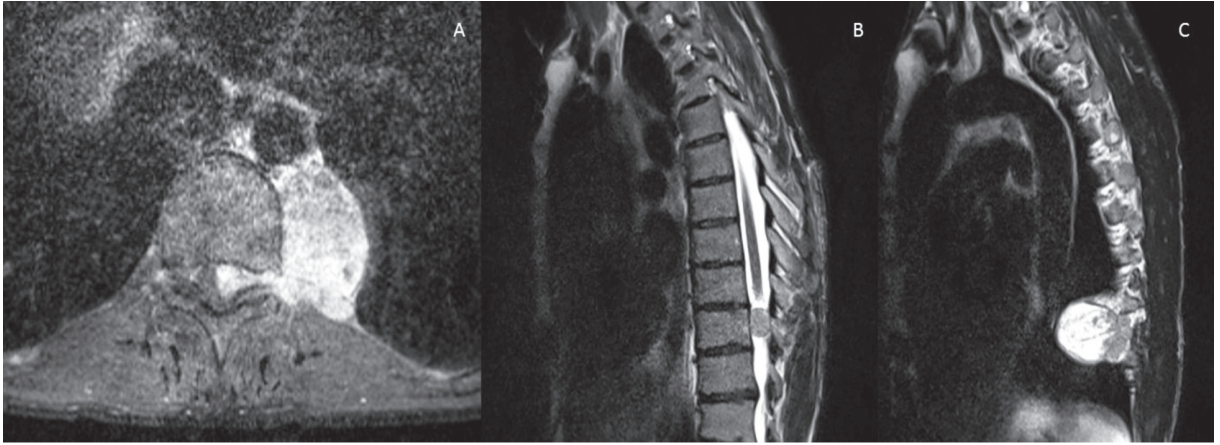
Preoperative MRI of the thoracic vertebra. The radiological imaging modality of choice was MRI of the thoracic vertebra and enhancing cystic tumoral lesions arising from the relevant neural foramen were observed (Figures 3A, 3B, 3C).
